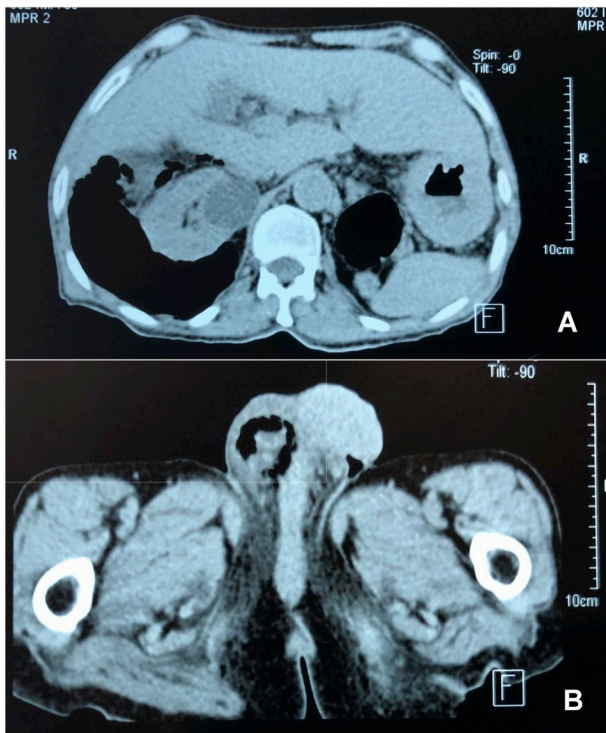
CT-scan of the abdomen showing large amount of air in the retroperitoneal space extending to the right scrotum.
